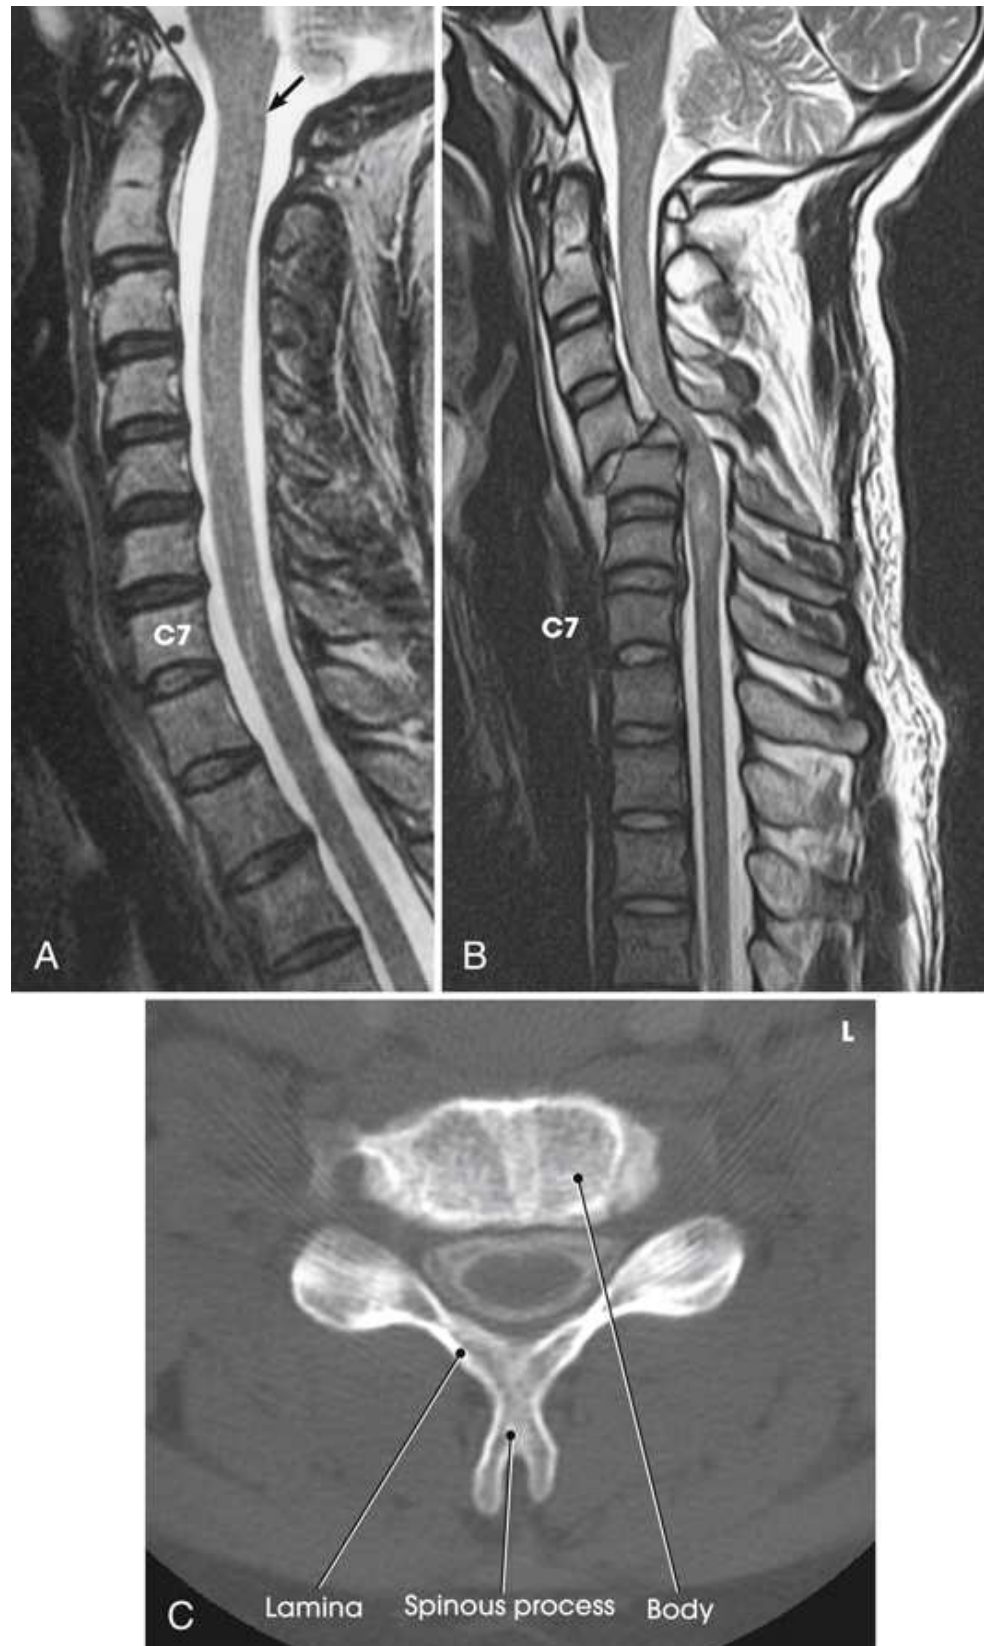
(A) MRI sagittal plane of cervical spine. Note position of spinal cord (*arrow*) in relation to vertebral bodies. (B) MRI sagittal plane showing anterior displacement of C4 on C5. Narrowed spinal canal compresses spinal cord causing paralysis. (C) Axial CT of typical cervical vertebra. B, Modified from Jackson SA, Thomas RM. *Cross-sectional imaging made easy*. New York: Churchill Livingstone; 2004. C, Modified from Kelley LL, Petersen CM. *Sectional anatomy for imaging professionals*, 2nd ed. St. Louis: Mosby; 2007.
